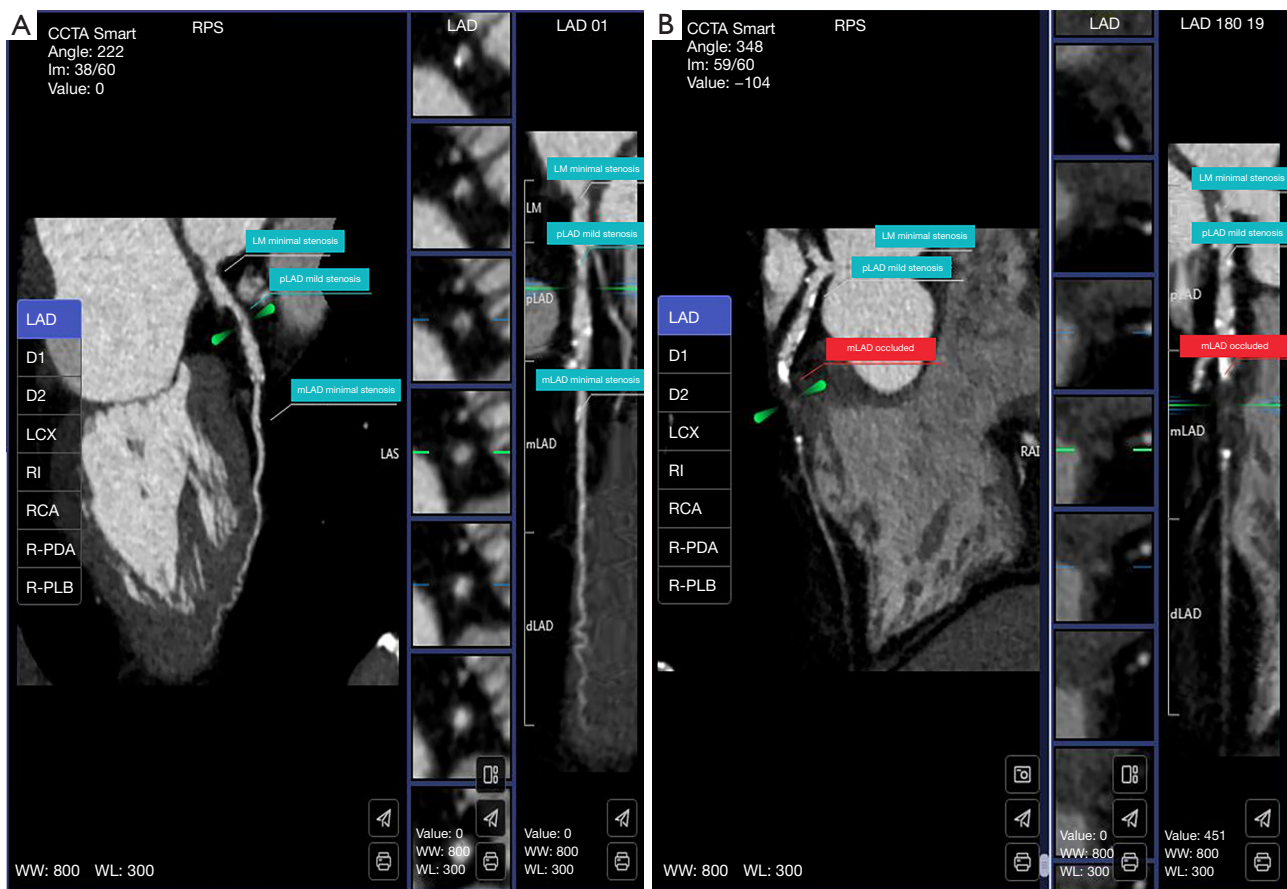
Example of the AI misrecognition of CTO lesion in a patient with a large vascular branch in close proximity to the occluded segment. (A) AI recognition errors occurred in LAD; (B) correct recognition of CTO lesion in LAD after manual adjustment. CCTA, coronary computed tomography angiography; LAD, left anterior descending artery; D1, first diagonal branch; D2, second diagonal branch; LCX, left circumflex artery; RI, ramus intermedius; RCA, right coronary artery; R-PDA, right posterior descending artery; R-PLB, right posterior lateral branch; WW, window width; WL, window level; LM, left main coronary artery; pLAD, proximal segment of the LAD; mLAD, middle segment of the LAD; dLAD, distal segment of the LAD; AI, artificial intelligence; CTO, chronic total occlusion.
